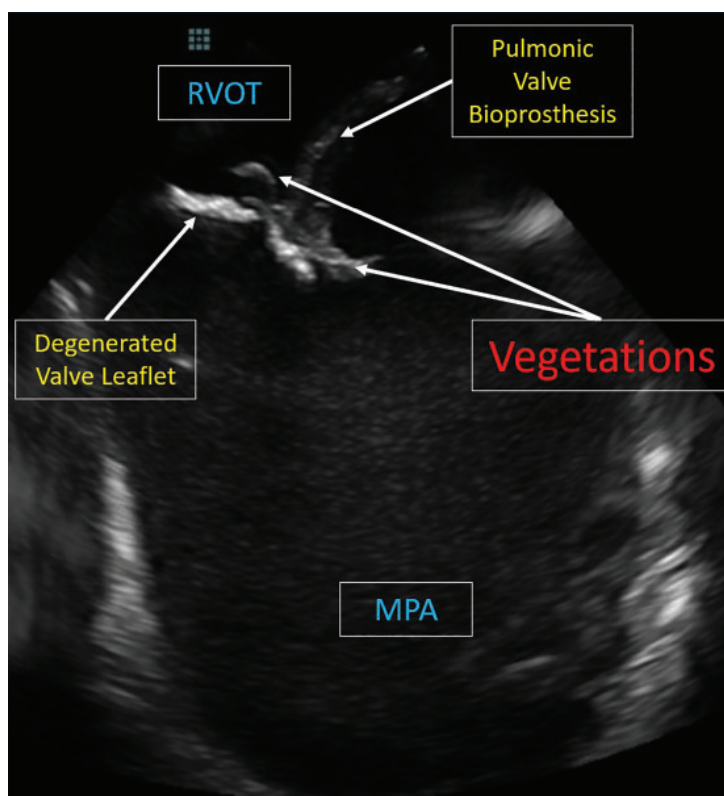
Intracardiac echocardiographic view of a pulmonic valve bioprosthesis in a 34-year-old man with repaired tetralogy of Fallot who presented with *Streptococcus mitis* bacteremia. Neither transthoracic nor transesophageal echocardiography could visualize valvular vegetations.
